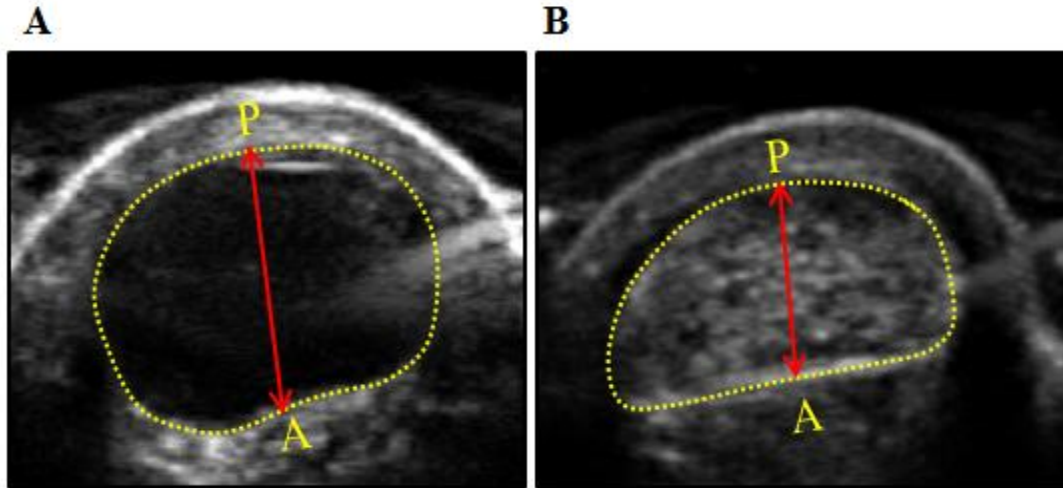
The transverse two-dimensional ultrasound images of a tendinopathic (A) and the corresponding control healthy matched Achilles tendon (B) at 60% of the tendon length in a patient with mid-portion Achilles tendinopathy. Yellow dotted line outlines the Achilles tendon cross-sectional area. Red solid double-headed arrow indicates tendon antero-posterior diameter. A; anterior, P; posterior.
